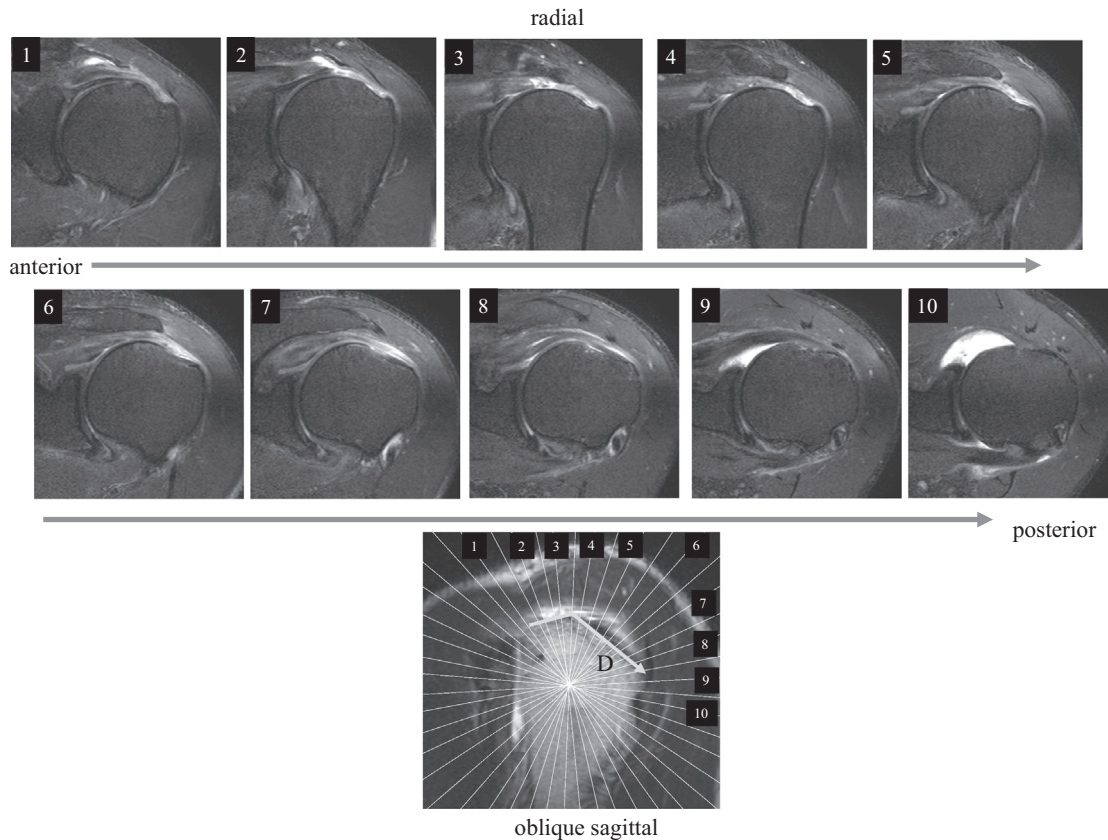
Radial MR images.
